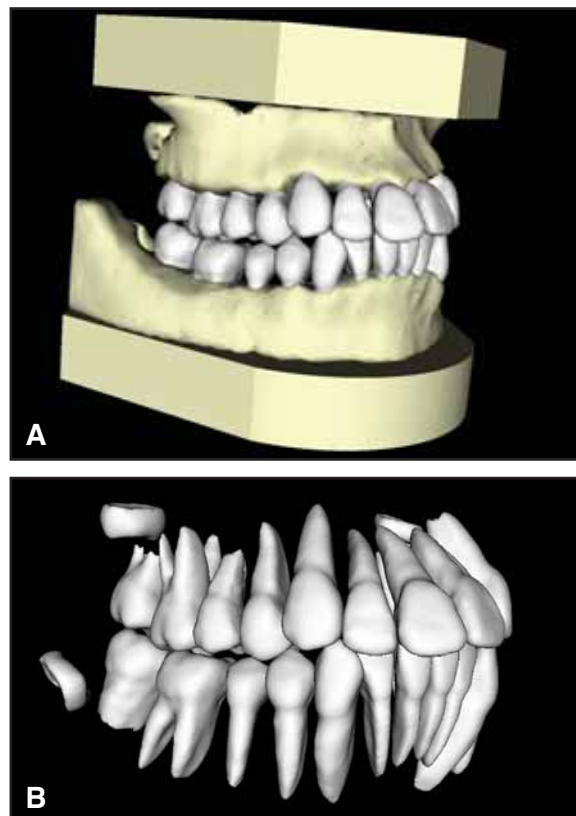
Virtual 3D study models created from CBCT data. A. Models with conventional bases. B. Models with transparent bases, allowing 3D visualization of complete dental crowns and roots. (Images provided by Anatomage, Inc.)
